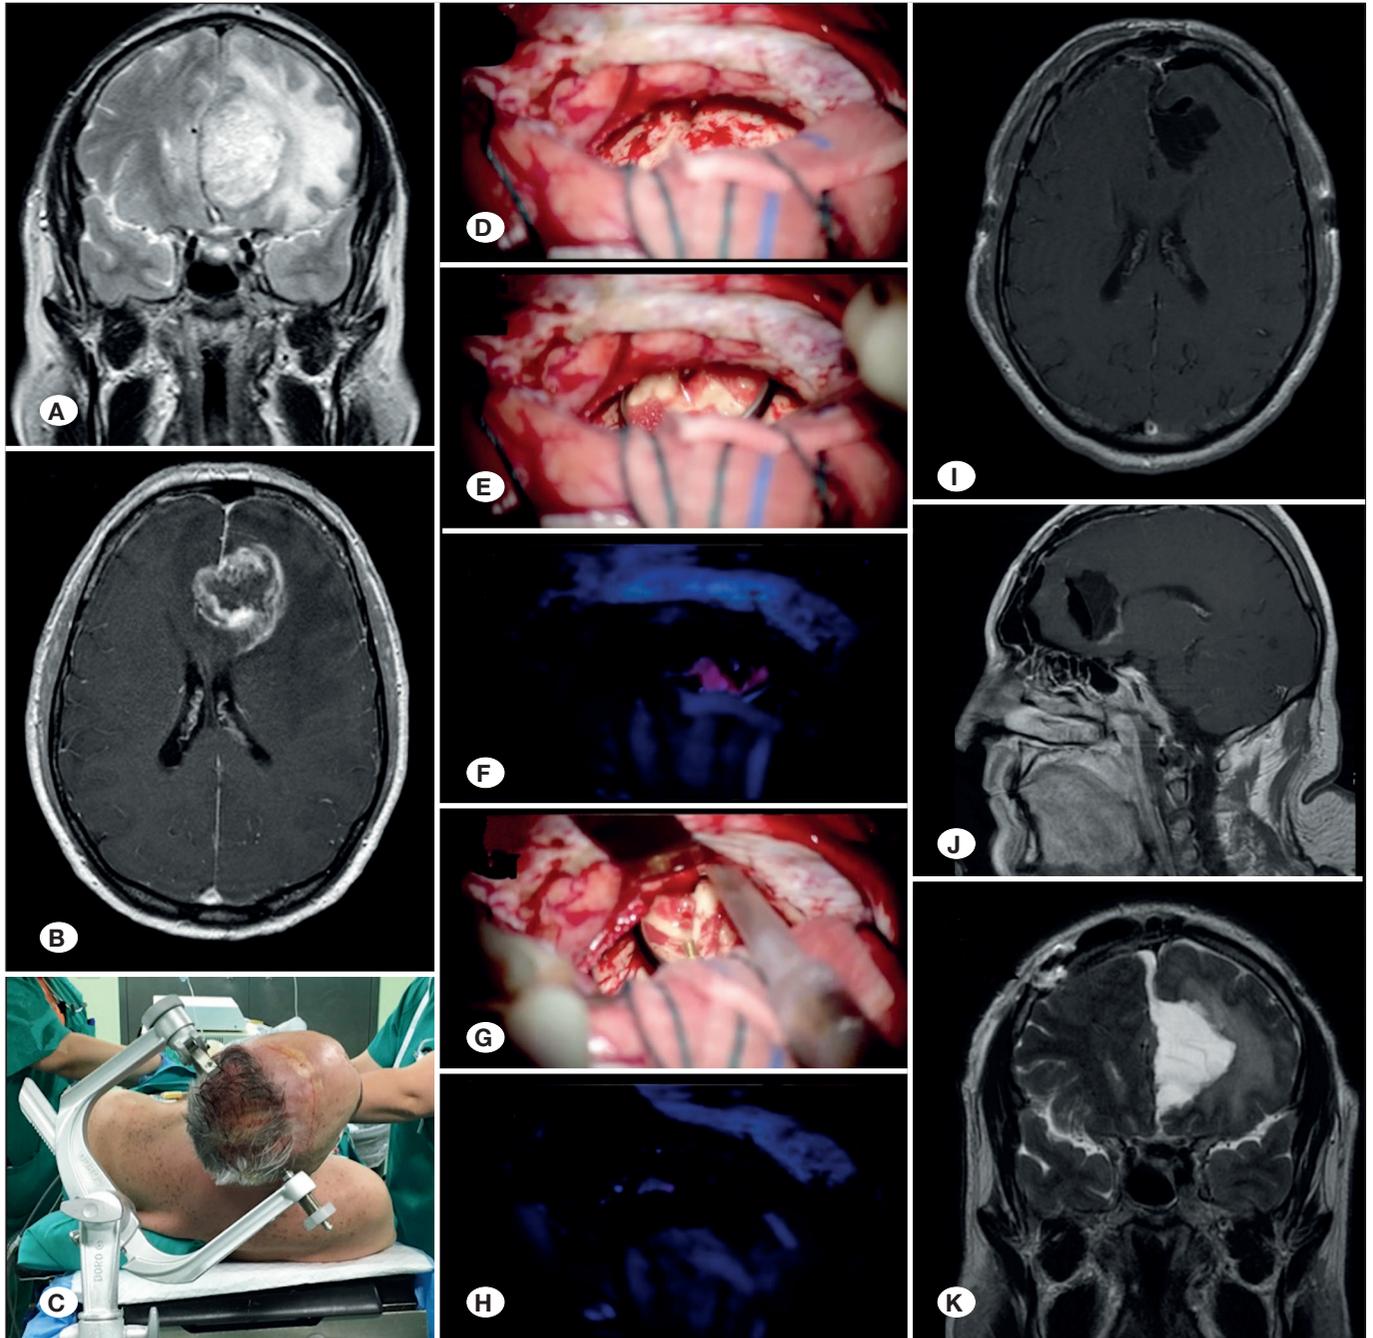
Preoperative A) coronal T2-weighted and B) axial T1-weighted gadolinium contrast-enhanced MRI. C) Surgical positioning. D-H) Sequential intraoperative pictures during 5-ALA-assisted tumor resection. Postoperative I) axial and J) T1-weighted contrast-enhanced MRI. K) Postoperative T2-weighted coronal MRI.
